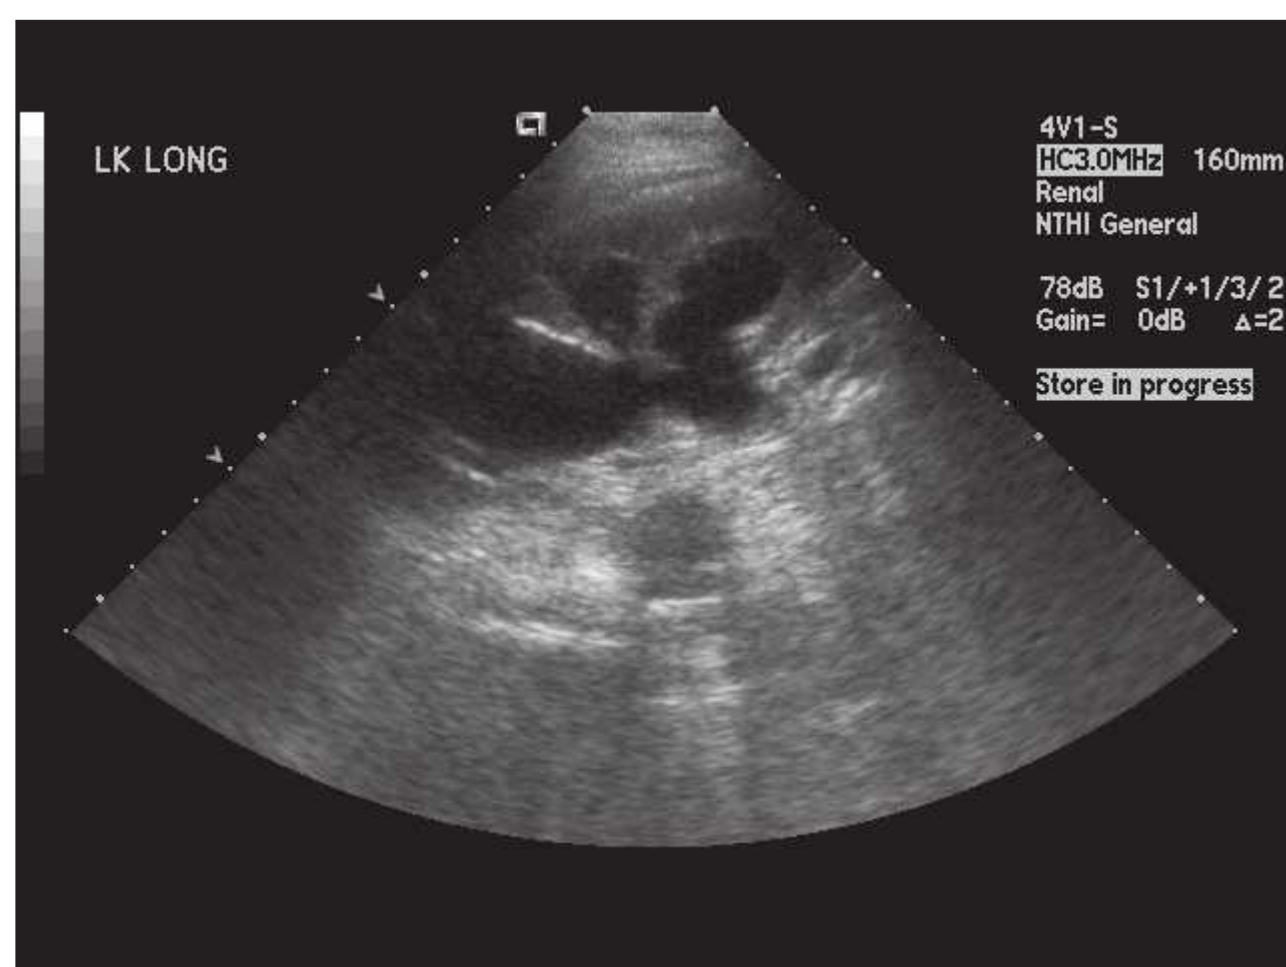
Arenal ultrasound photo showing hydroureteronephrosis of a left kidney due to a bladder outlet obstruction in a patient with known prostate cancer.
